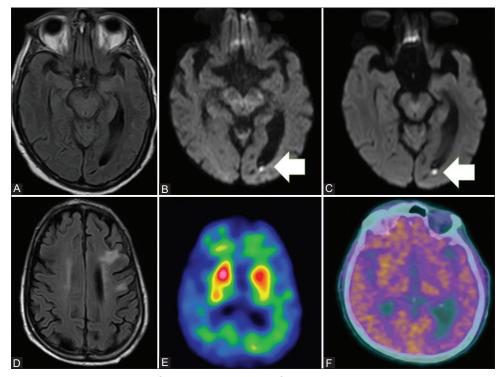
Panel A: FLAIR MRI image – normal on day 2. Panel B: DWMRI on day 2 shows restricted diffusion in the dependent portions of the occipital horn of the lateral ventricle. (White arrow) Panel C: DWMRI on day 10 shows persistent restricted diffusion in the left occipital horn of the lateral ventricle. (White arrow) Panel D: Stable old left sub-cortical white matter hyperintensities. Panel E: 99mTc-TRODAT SPECT scan – significantly reduced tracer uptake noted in both putamens (right > left). Mildly reduced tracer uptake in the left caudate nucleus. Panel F: 18FDG PET-CT image – diffusely reduced FDG uptake in both cerebral and cerebellar hemispheres, basal ganglia, and thalami
